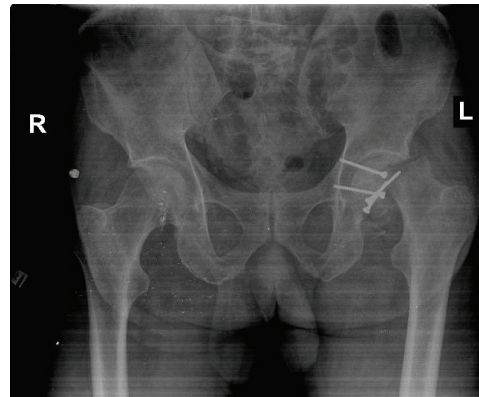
Antero-posterior pelvis radiography film made 9 months after the injury after sudden pain in the hip: subcapital stress fracture of the neck of the left femur at the place with no previous fracture.
